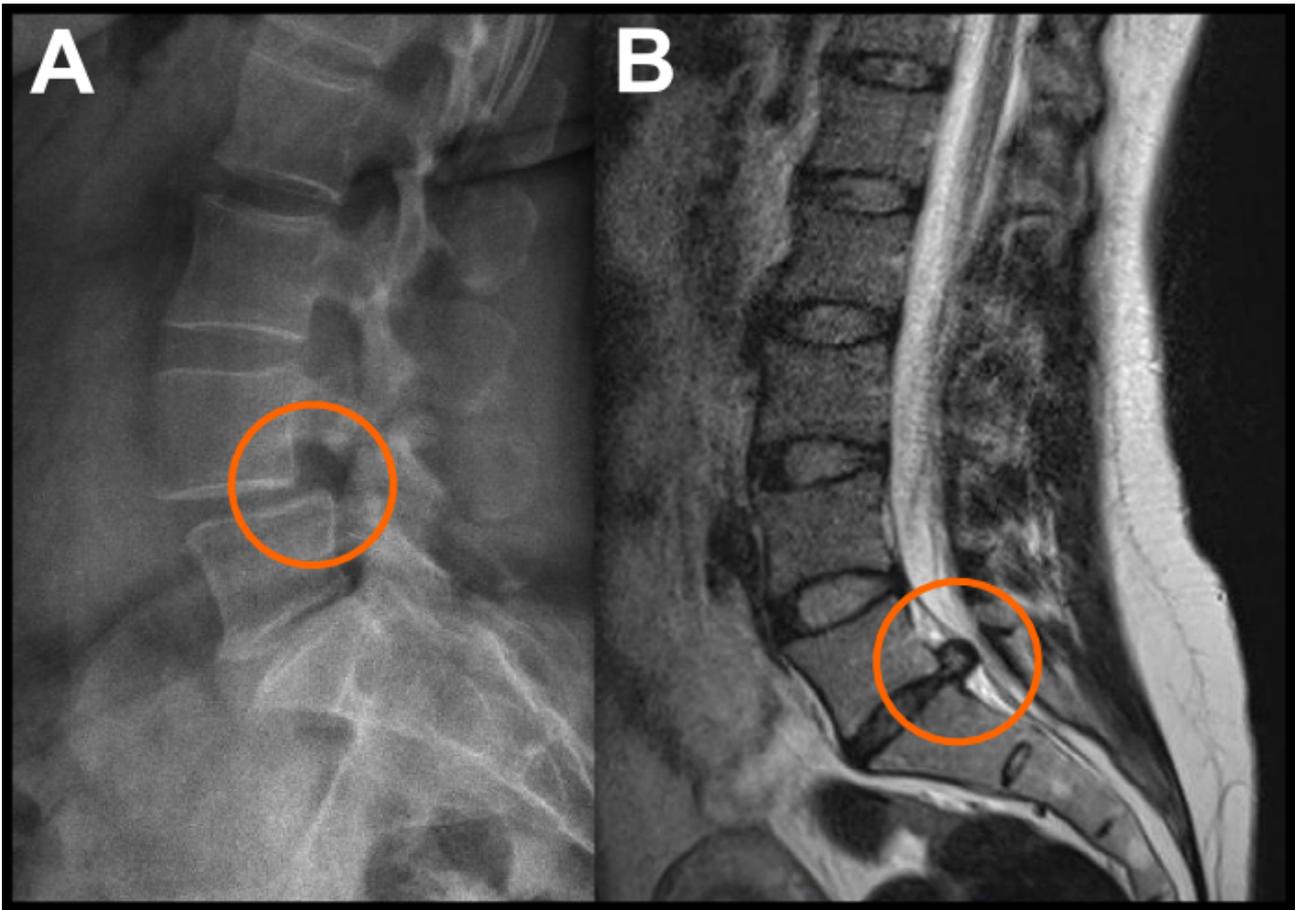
A – X-ray picture of ventrolisthesis L4; B – MRI of disc herniation L5/S1
